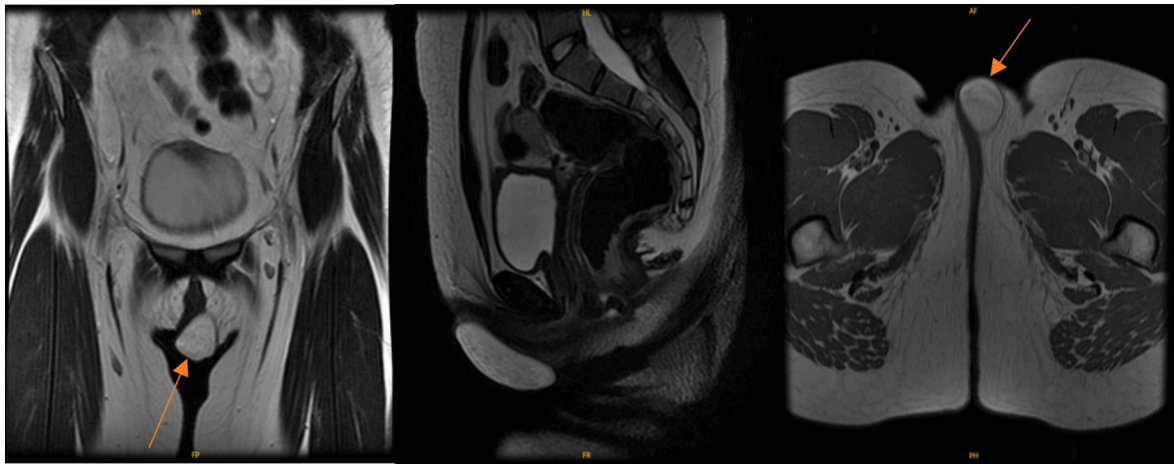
MRI of Pelvis showing faintly contrast enhancing lipomatous mass along the left labia majora.
